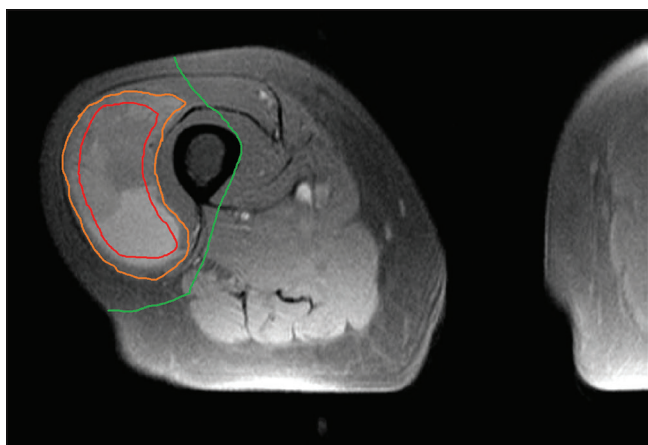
Axial MRI showing surgical margins of a right-sided thigh undifferentiated pleomorphic sarcoma. Red circle (innermost) represents an intralesional margin. Yellow circle (2nd from center) represents a marginal excision. Green circle (outermost line) represents a wide excision
